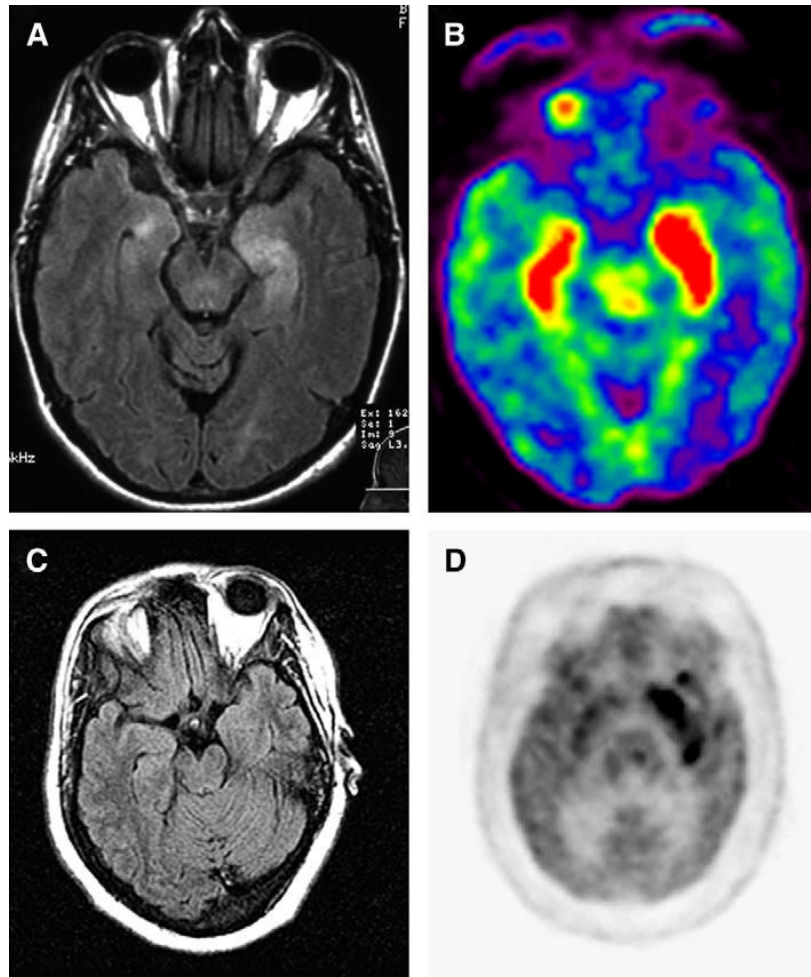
MRI and FDG-PET in patients who have paraneoplastic limbic encephalitis (A) (brain MRI) and (B) (FDG-PET) of a patient who had SCLC and anti-Hu associated paraneoplastic limbic encephalitis; note that there is bilateral medial temporal lobe FLAIR hyperintensity that correlates with FDG hyperactivity (*red*) in the PET study. (C) Brain MRI and (D) FDG-PET of a patient who had paraneoplastic encephalitis associated with carcinoma of the thymus; in this patient the PET study revealed an extensive area of FDG hyperactivity (dark signal in the medial left temporal lobe) that was not noted in the MRI.
